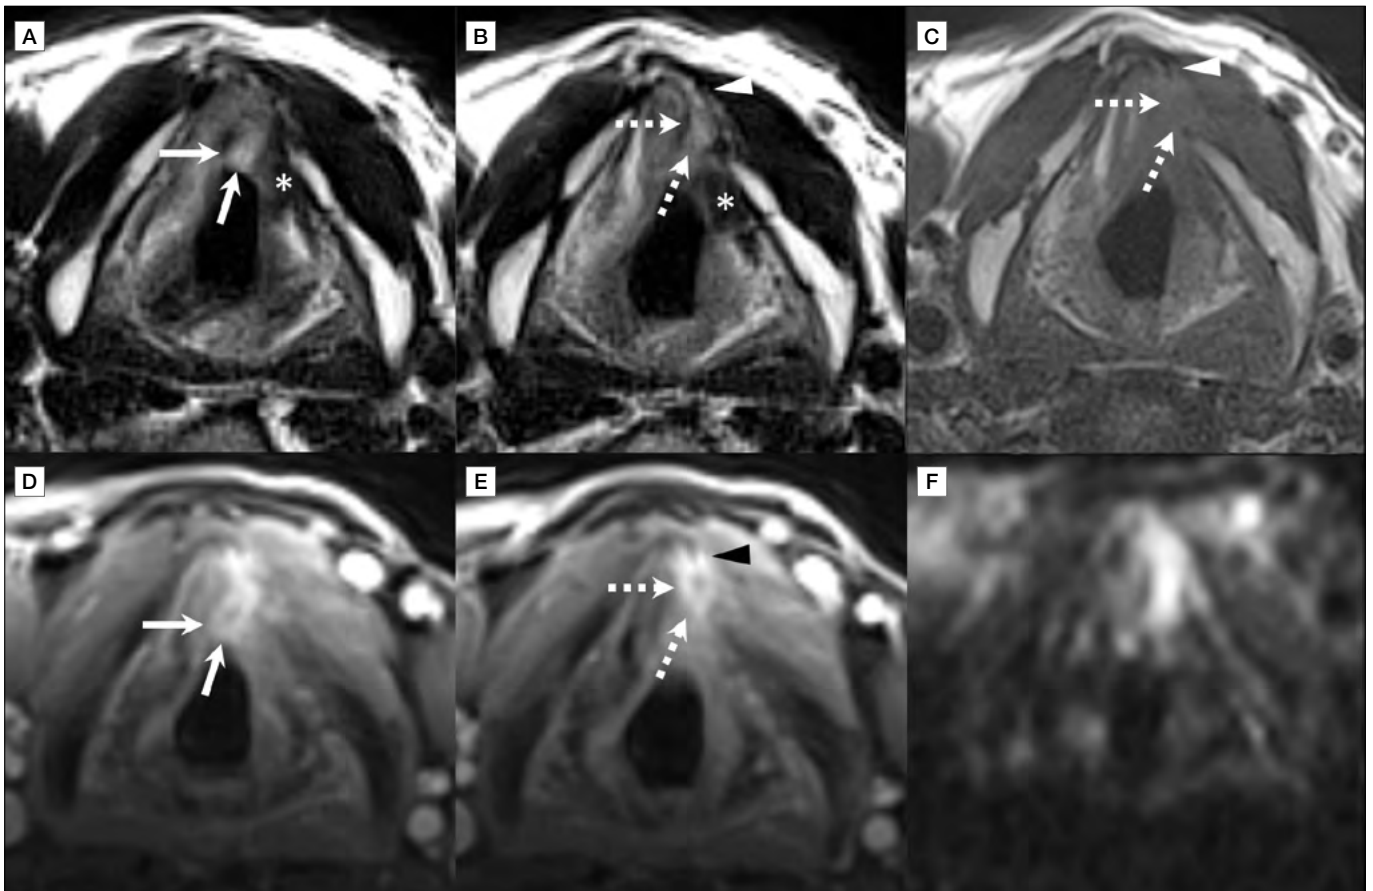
Focal post-CO₂ TOLMS LC in patient No. 3. Axial images at the glottic level (A, D and F) and immediately superior supraglottic level (B, C and E): T2-weighted (A and B), T1-weighted (C), contrast-enhanced fat-saturated T1 (VIBE) (D and E) and DWI b900 (F). Focal para-commissural lesion (arrows in A and D) at the residual left vocal cord, anterior to the T2 hypointense signal region of the cordectomy scar (asterisks in A and B). It extends deeply and involves the full thickness of the adjacent anterior thyroid lamina (dotted arrows in B, C and E). Notice slight extension along the external surface of the thyroid lamina anteriorly (arrowheads in B, C and E). This lesion shows slightly elevated T2-weighted signal, low T1-weighted signal, intense peripheral contrast enhancement and minimal diffusion restriction pattern (mean ADC value of $1.1 \times 10^{-3} \text{ mm}^2/\text{s}$; ADC map not shown). While this lesion could be misdiagnosed as tumour recurrence, a biopsy confirmed post-CO₂ TOLMS thyroid chondritis.
